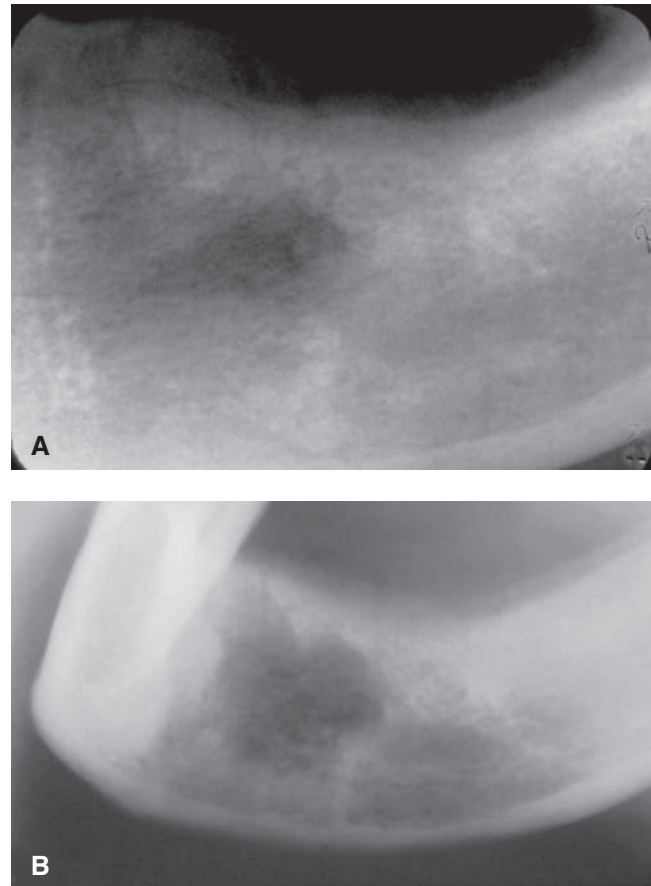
Metastatic cancer. Radiographs A and B show different views of the same radiolucent lesion with poorly defined margins representing a metastatic breast cancer. (Courtesy of Dr. Robert P. Langlais.)
